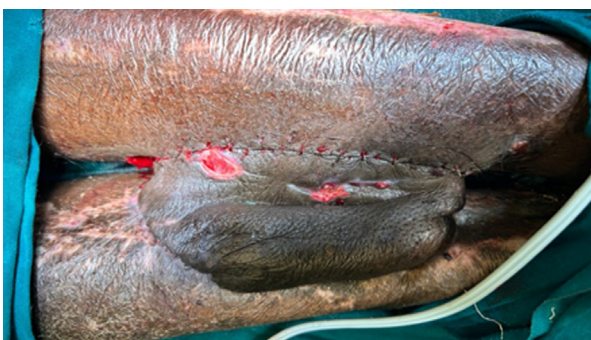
Identification of Perforator of the cross-leg flap by doppler
